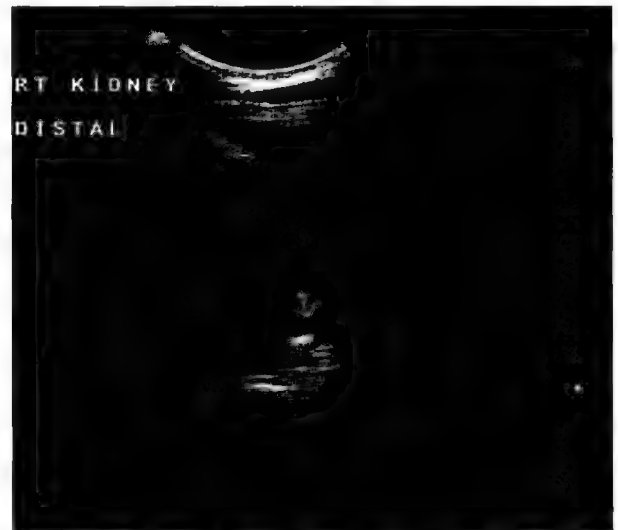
Ultrasound scan of the right kidney of the current patient showing dilatation of the renal pelvis and an echogenic lesion (arrowed) at the pelviureteric junction, associated with an acoustic shadow beneath it. The denser an object is in relation to water the brighter it appears on ultrasound (echogenic). Note how the contents of the renal pelvis (urine) appear black, that is, non-echogenic.
